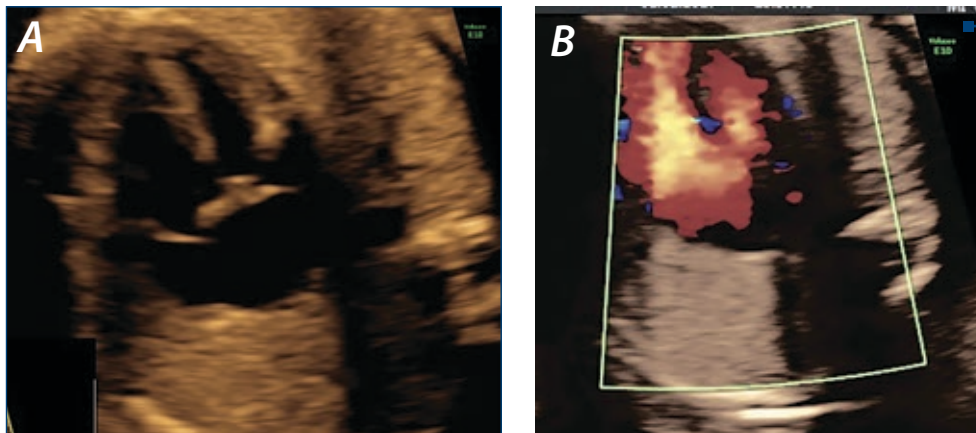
(A and B). Heart defect which shows an atrioventricular septal defect, with size discrepancy between left and right. On the Color Doppler flow there is almost absent flow on the mitral valve and the filling of the left ventricle is through the ventricular septal defect
